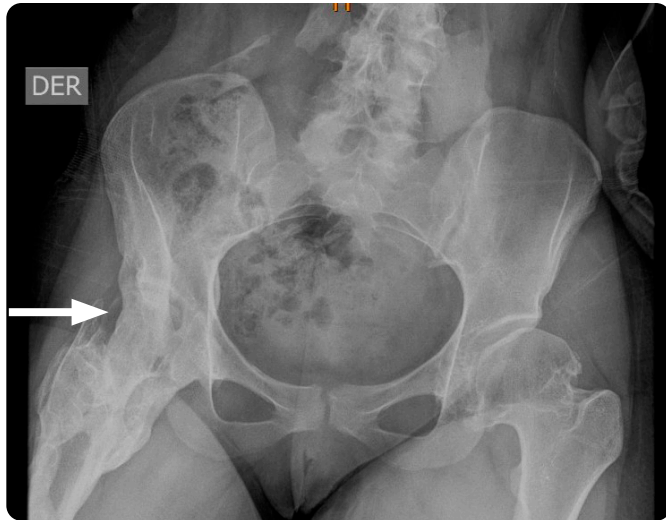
X-ray of the pelvis, anteroposterior projection. Extensive bony plate joining the iliac bone and the right femur (arrow), causing severe immobilization of the right coxofemoral joint, with almost complete joint fusion.
